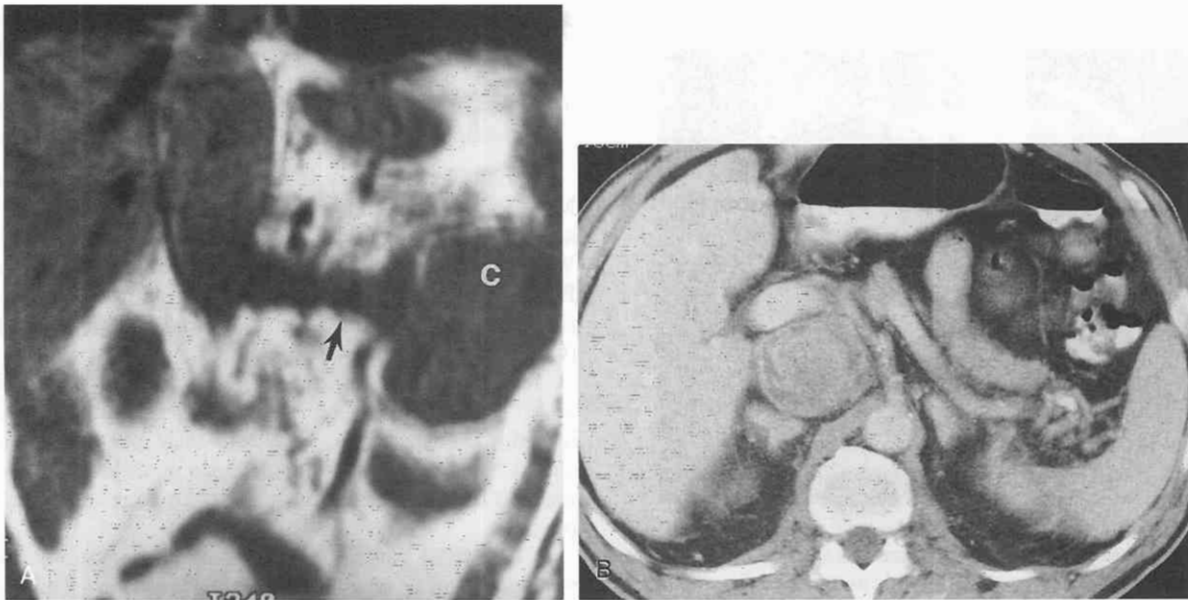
Inferior vena cava thrombus. *A*, Coronal T1-weighted MR image of a large left renal cancer (C) in a 68-year-old man reveals a large amount of thrombus extending into the left renal vein (arrow) and inferior vena cava. *B*, A contrast-enhanced CT image through the inferior vena cava thrombus demonstrates it to be very heterogeneous because it contains areas of contrast enhancement. This indicates that tumor thrombus (which contains its own blood vessels) is present. Identification of a tumor thrombus, rather than a bland thrombus, does not necessarily alter subsequent treatment.
